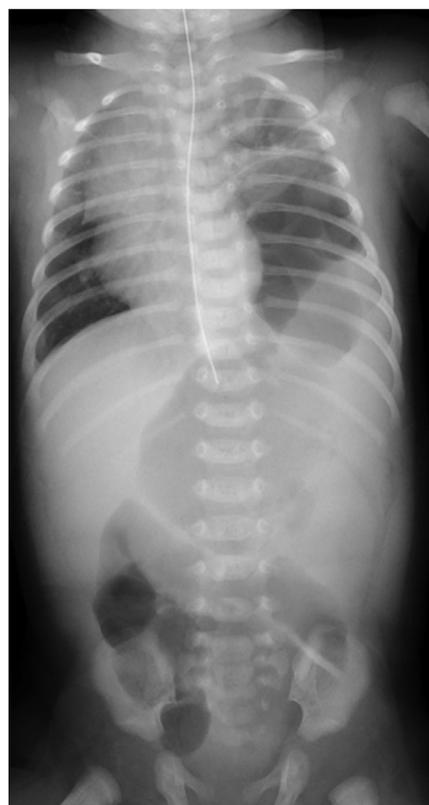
Late-presenting congenital diaphragmatic hernia. The chest radiograph shows intestinal gas in the left thoracic cavity, compressing the heart rightwards.
